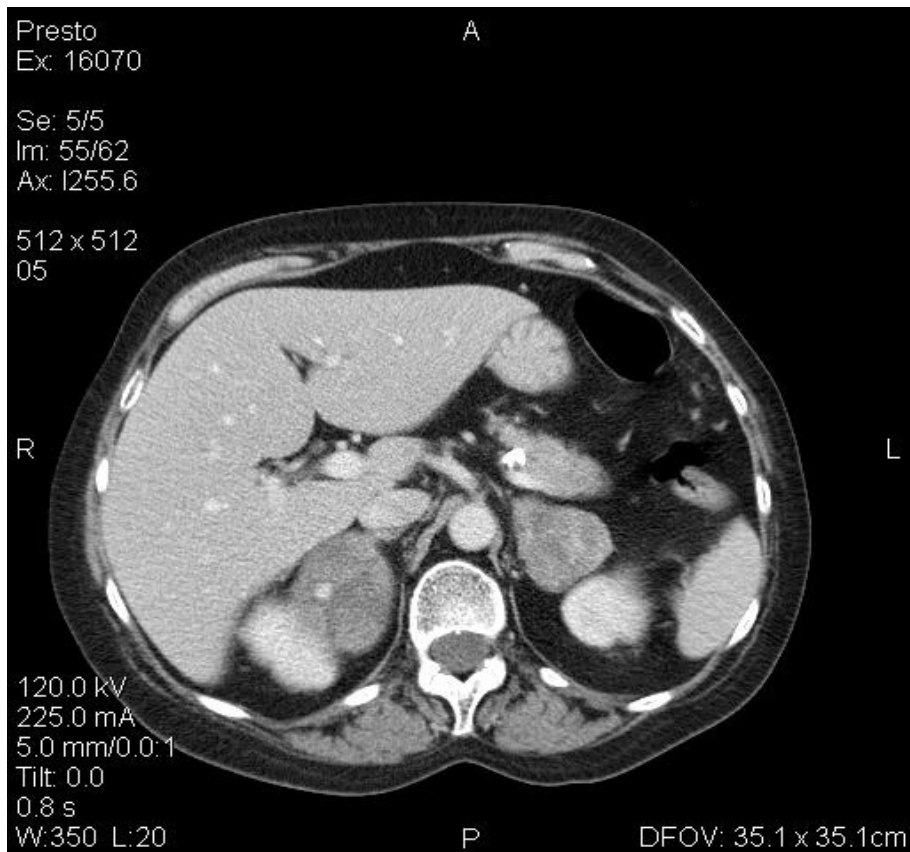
Postcontrast CT, axial section, non-homogeneous secondary haematogenic determinations, in the adrenal glands
